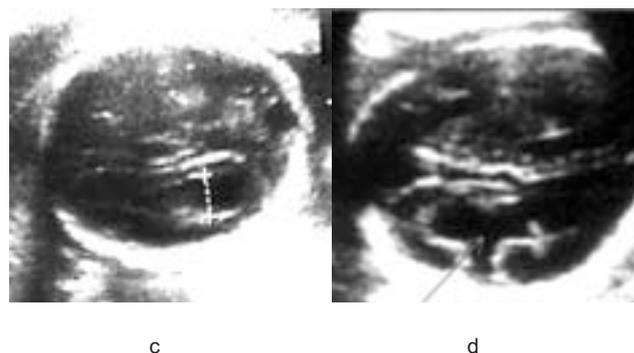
Fetal ultrasonographic pictures showing (a) a single ventricle in holoprosencephaly, (b) Dandy-Walker malformation: posterior fossa cyst communicating with fourth ventricle and flattened cerebellar hemispheres (c) Distended posterior horns of lateral ventricles in a fetus with aplasia of corpus callosum and (d) Schizencephaly - Cleft in the cerebral hemisphere due to abnormality of neuronal migration.
